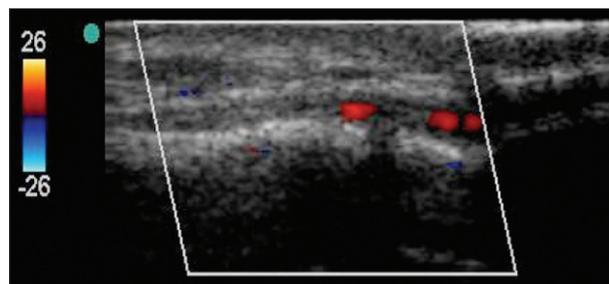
Ultrasound imaging of the dorsalis pedis artery.
